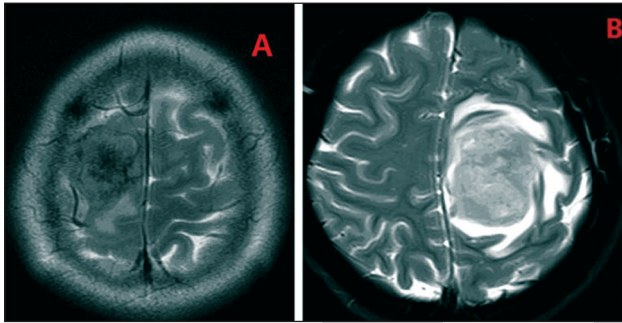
A RDD was hypointensity on T2 MRI; B: meningioma was hyperintensity on T2 MRI.
